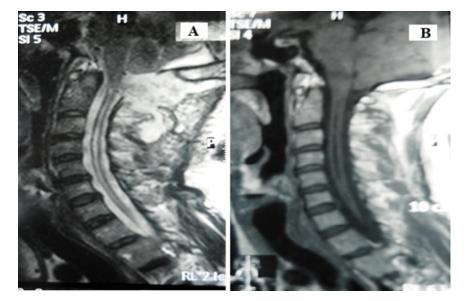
A, Post Op. MRI Sagittal view T1weighted image and B, T2 weighted image showing regression of CM and SM.
